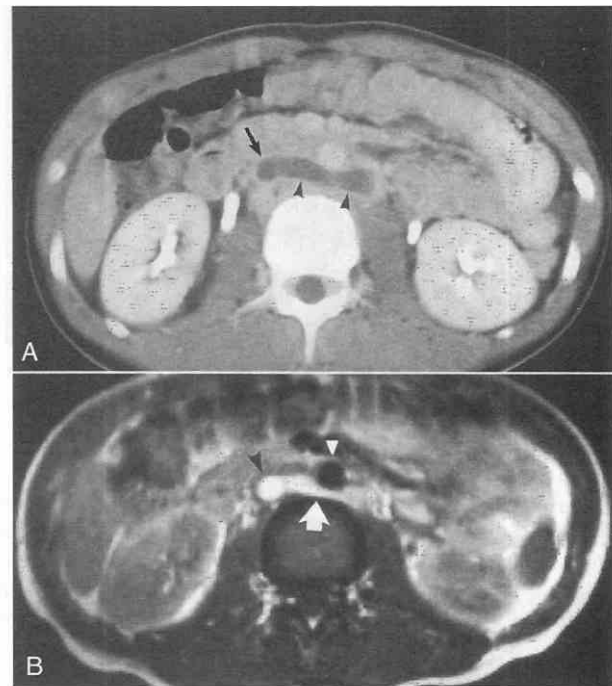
Renal vein thrombosis associated with the nephrotic syndrome. A, Low-density thrombus is present in a retroaortic left renal vein (*arrowheads*) and in the adjacent inferior vena cava (*arrow*). B, Spin-echo MR image (TR = 650 msec, TE = 30 msec) shows high signal thrombus in the retroaortic left renal vein (*arrow*) and in the adjacent inferior vena cava (*black arrowhead*). The aorta (*white arrowhead*) shows normal blood flow.
